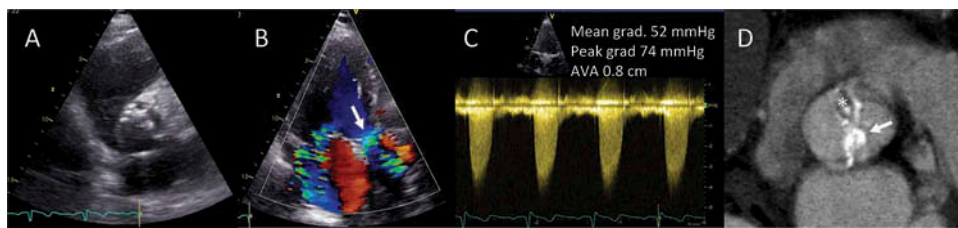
Bicuspid aortic valve stenosis. Example of a 75-year-old female complaining of dyspnea. On transthoracic echocardiogram, the parasternal short-axis view showed a calcified aortic valve with probable bicuspid morphology (panel A). On the apical 3-chamber view, a turbulent systolic flow through the aortic valve was observed (panel B, arrow) and the continuous wave Doppler showed a dense spectral signal with a peak velocity of 4.2 m/s and calculated mean and peak gradients of 52 mmHg and 74 mmHg, respectively (panel C). The aortic valve area (AVA) is 0.8 cm². On multi-detector row computed tomography (panel D), the anatomy of the aortic valve was better delineated, showing a type 0 bicuspid aortic valve with a calcified commissure (arrow) and a small opening (asterisk). Abbreviations: AVA = aortic valve area.
